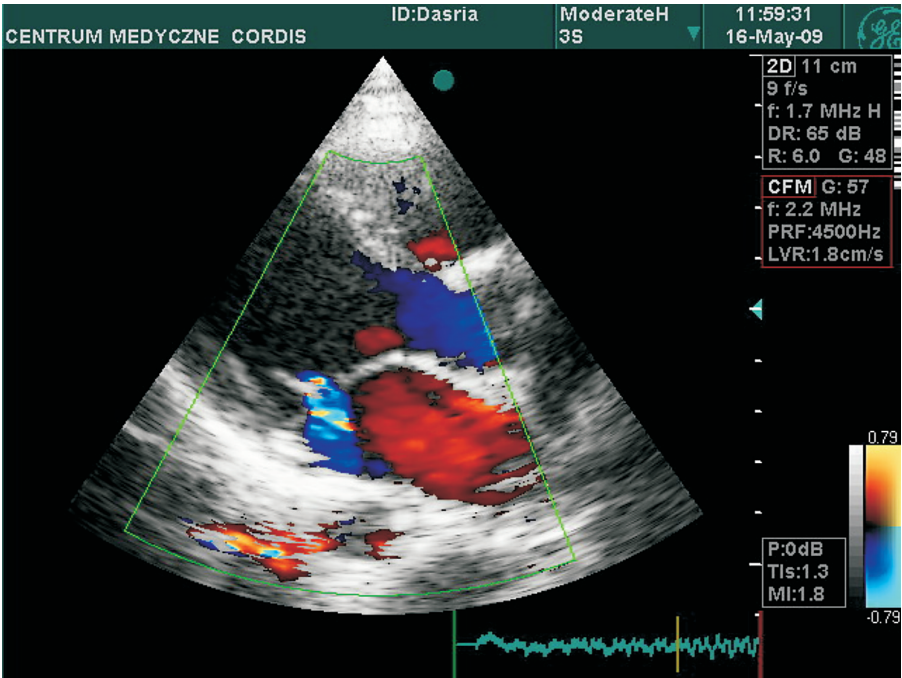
Echocardiography. Isolated mitral valve insufficiency (MI)
